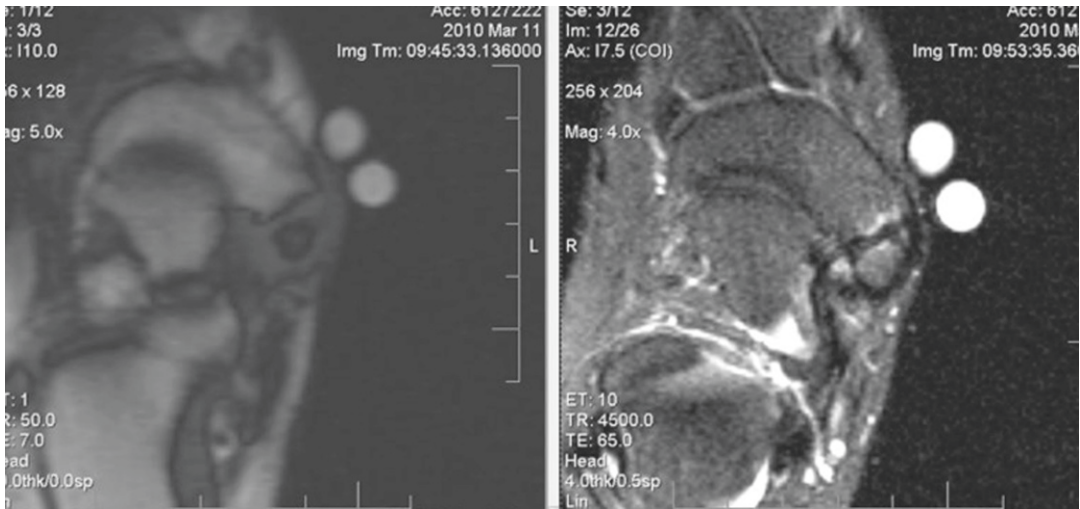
T2- and T1-weighted MRI sequences in a male soccer player complaining of medial foot pain. Imaging demonstrated the presence of an accessory os navicular
